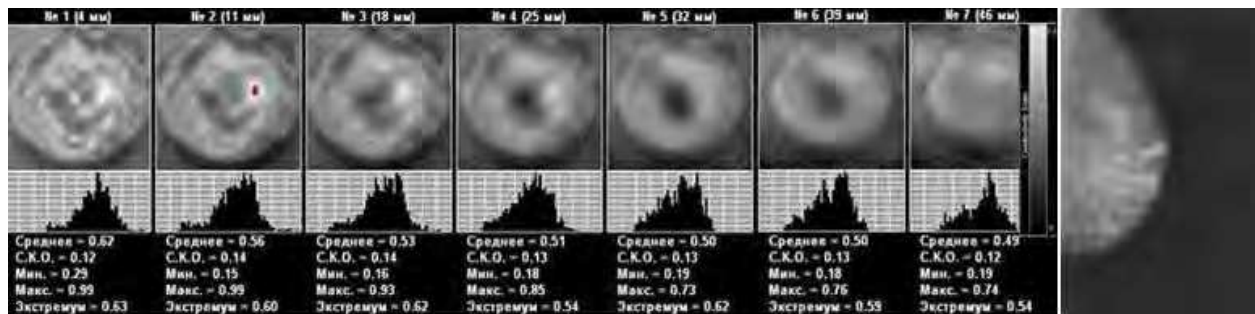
EIM. Seven scan planes. A 52 years-old patient. Amorphous type of mammary gland structure. High values of mean electrical conductivity index – (> 90 pct). On the right - X-ray mammogram.
